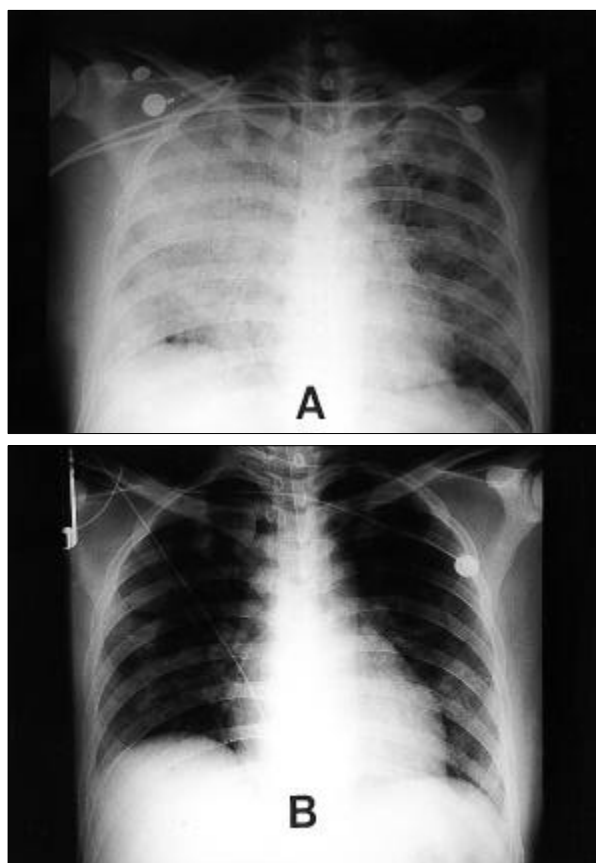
Rapidly cleared, diffuse infiltrations on chest radiography between the 1st(A) and the 3rd(B) day after first admission.
